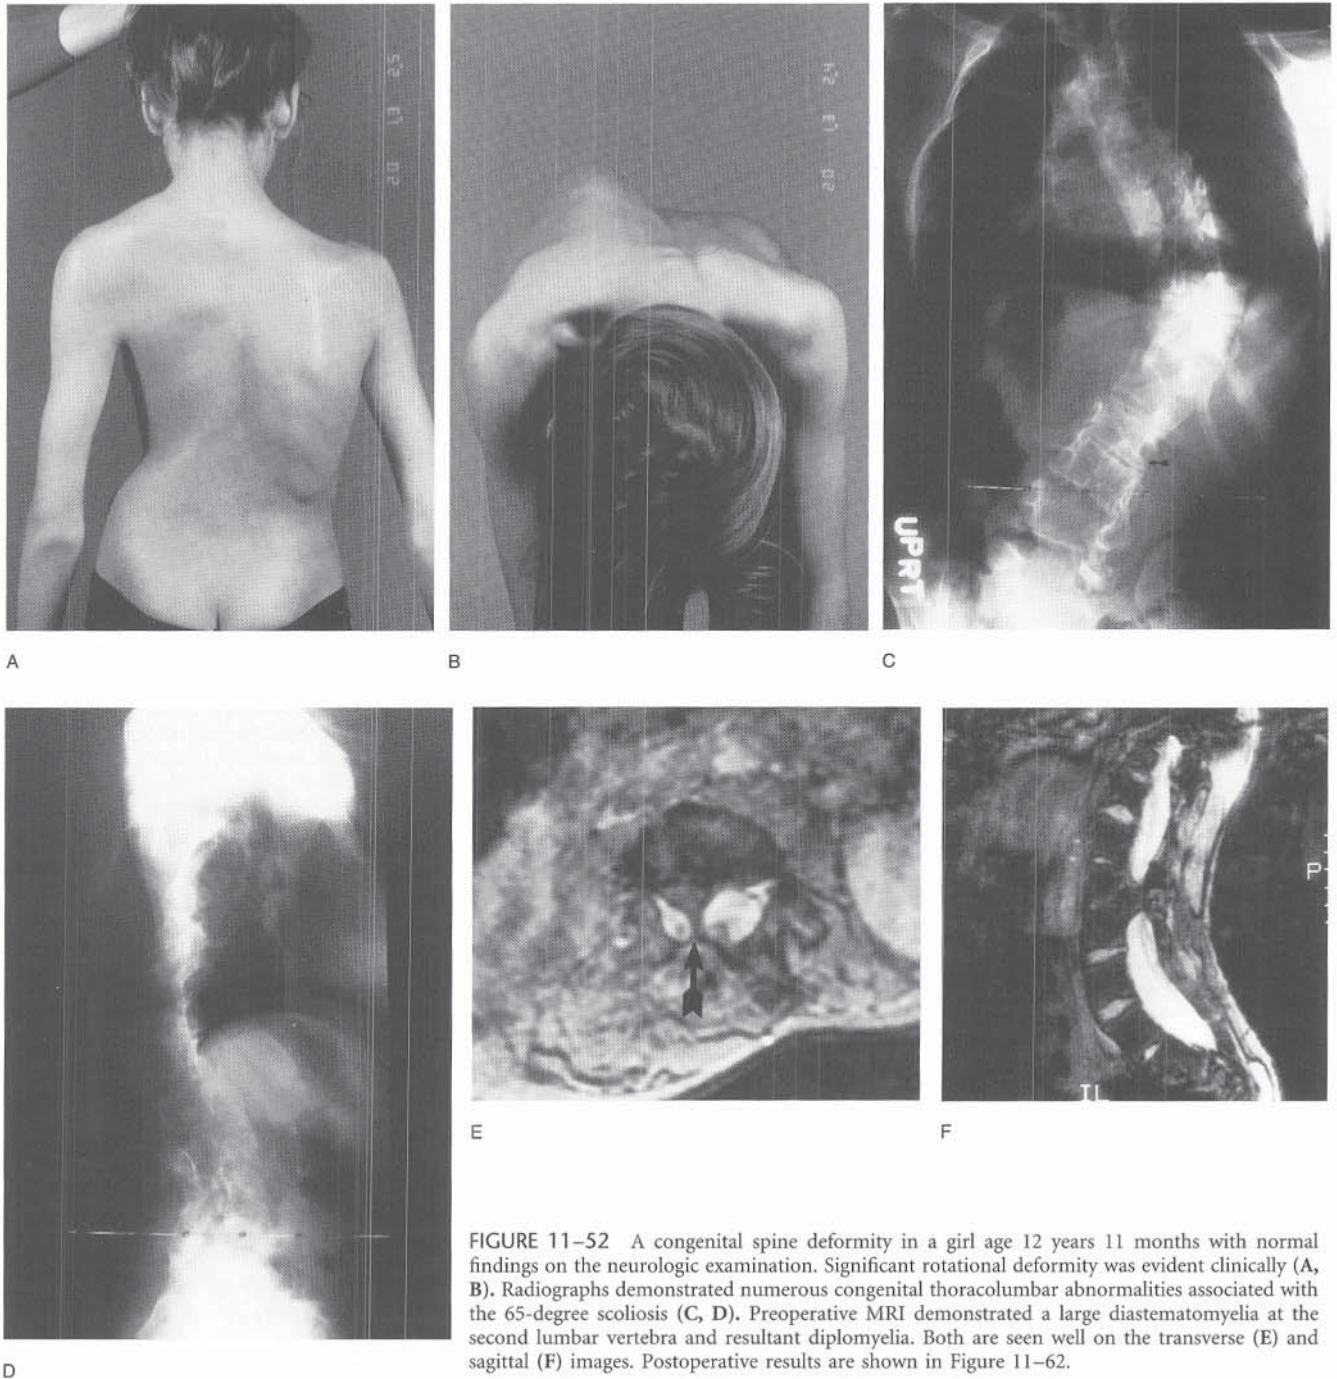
A congenital spine deformity in a girl age 12 years 11 months with normal findings on the neurologic examination. Significant rotational deformity was evident clinically (A, B). Radiographs demonstrated numerous congenital thoracolumbar abnormalities associated with the 65-degree scoliosis (C, D). Preoperative MRI demonstrated a large diastematomyelia at the second lumbar vertebra and resultant diplomyelia. Both are seen well on the transverse (E) and sagittal (F) images. Postoperative results are shown in Figure 11-62.
